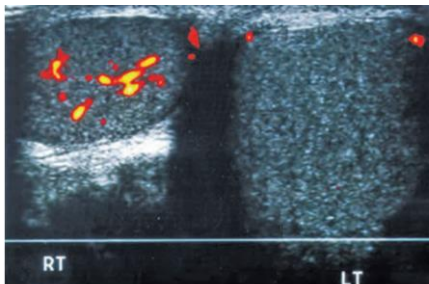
Doppler studies in testicular torsion (left - marked reduction of blood flow)
